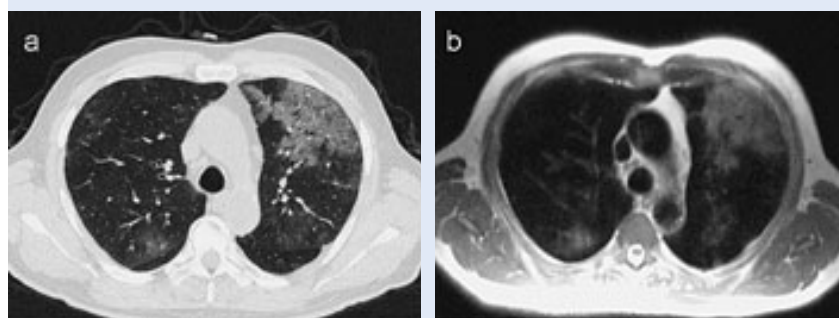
Ground glass infiltrate in immunosuppressed patient. Multi-detector HR-CT (a) and iPAT HASTE MRI (b).
